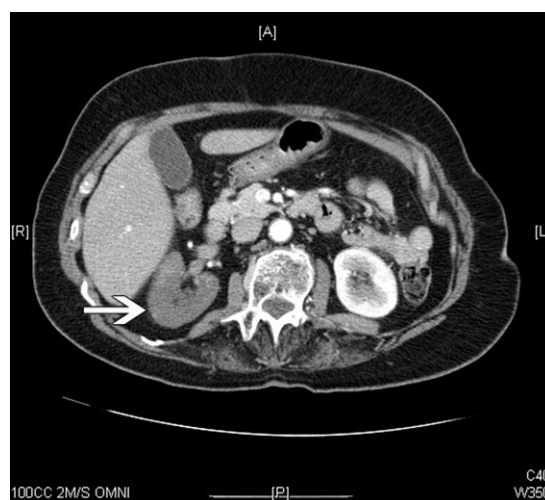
Computed tomography of the abdomen showing no contrast uptake by the lower pole of the right kidney.
